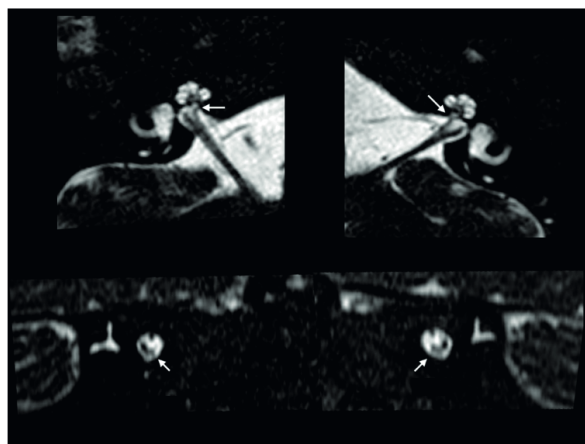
MRI findings of bilateral hypoplastic cochlear nerves: 3D axial DRIVE and reformatted parasagittal oblique images show within the antero-inferior aspect of the IAC fundus a hypoplastic cochlear nerve (white arrow) of smaller diameter than the facial nerve.
